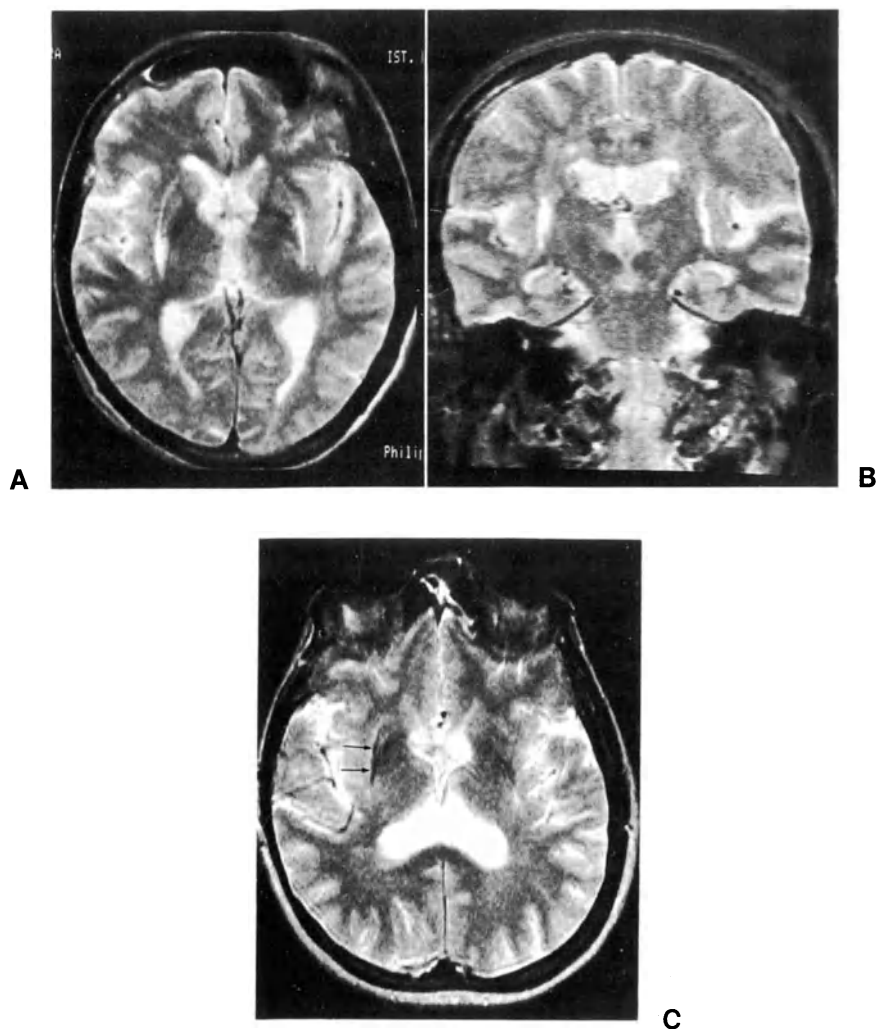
Multiple system atrophies. In 0.5 T studies, high signal intensity consistent with increased amounts of water is observed (A axial, and B coronal T2-weighted sections in a case of Shy-Drager syndrome; same patient as in Fig. 6C and D. [From *J Comput Assist Tomogr* (Savoiardo et al., 1989), with permission.] In a case of striatonigral degeneration, low signal intensity particularly in the right putamen is present (C axial T2-weighted section, arrows)
